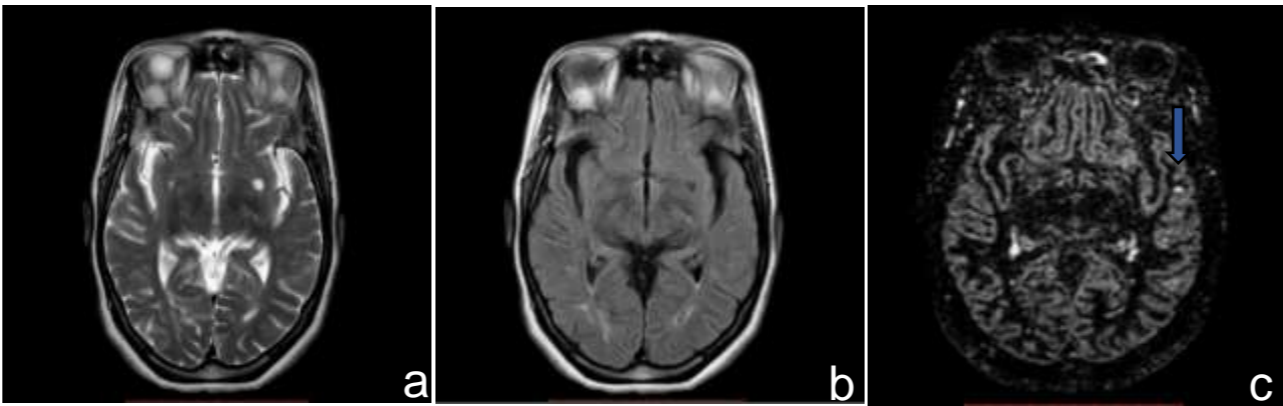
Small demyelinating cortical lesion seen at left temporal region clearly identified on 3D DIR (c) (blue arrows) and couldn't be visualized on both T2WI (a) and FLAIR (b).
